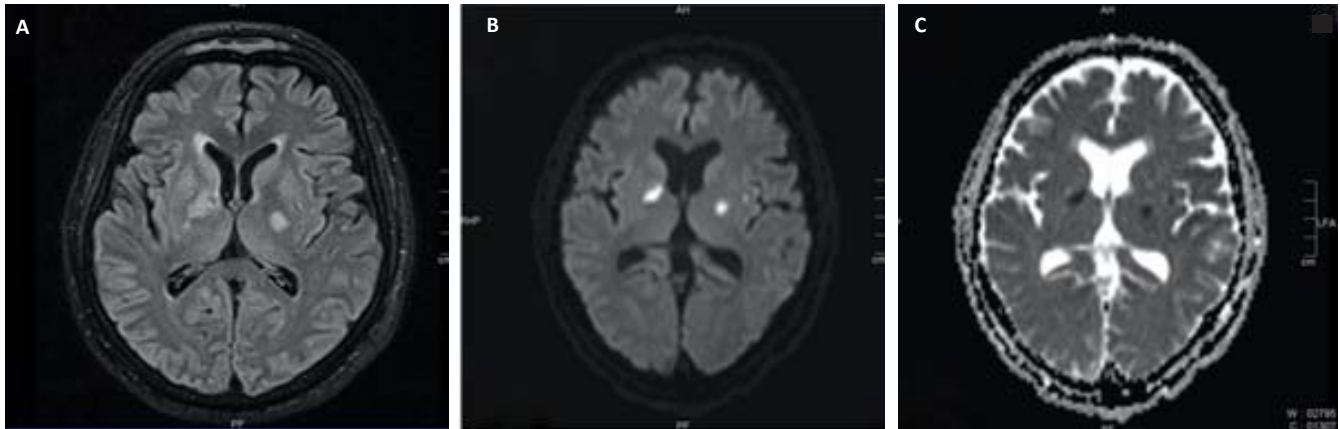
A. T2 FLAIR, B. DWI, and C. ADC images demonstrate bilateral T2 FLAIR high signal intensities involving the left internal capsule, right globus pallidus, and bilateral external capsules. This shows diffusion restriction suggesting acute infarcts.
